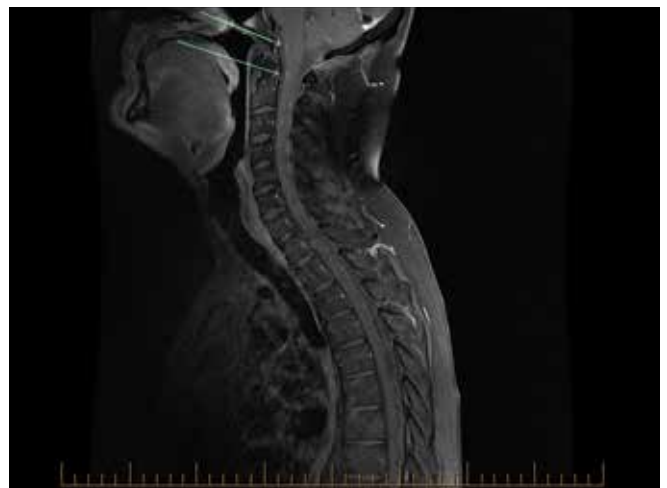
MRI spine sagittal T1 with contrast showing bulky deposits along the cranial nerves VI, VII and VIII
